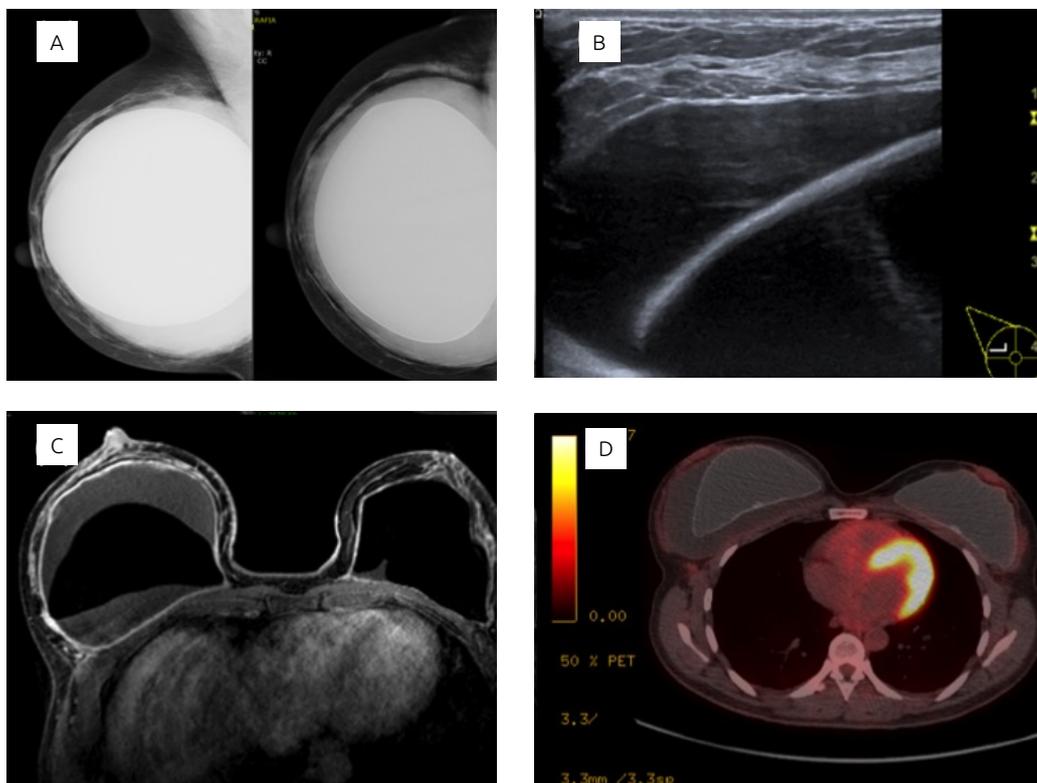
Negative radiological findings: (A) mammography; (B) breast ultrasound; (C) magnetic resonance; (D) positron emission computed tomography.
